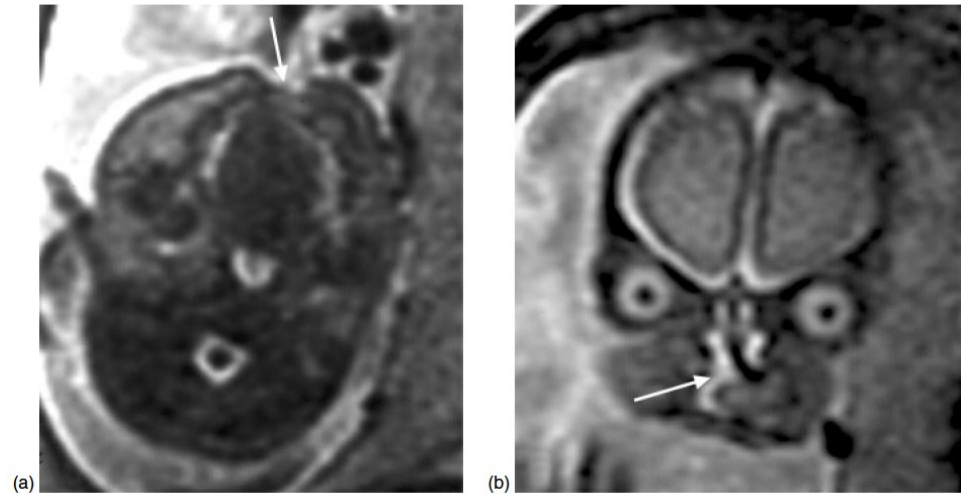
T2-weighted MRI of a fetus with unilateral cleft lip and palate: (a) the defect in the lip (arrow) is imaged in the axial section and (b) coronal view: the nose is distorted contralaterally to the cleft lip (arrow) and this indicates the involvement of the anterior palate (alveolus)
